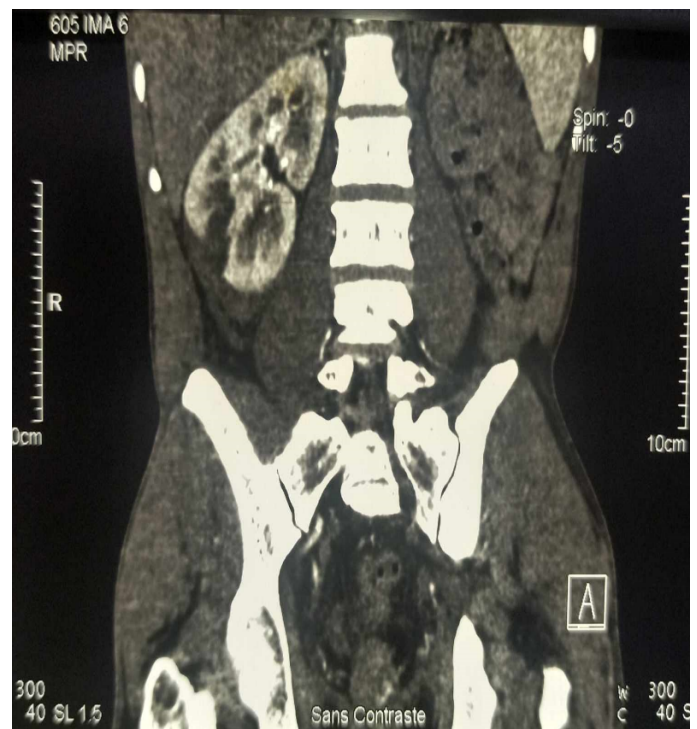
Follow-up contrast-enhanced CT urography on day 7. Marked regression of the subcapsular and perirenal hematoma, with no new extravasation or complication.
